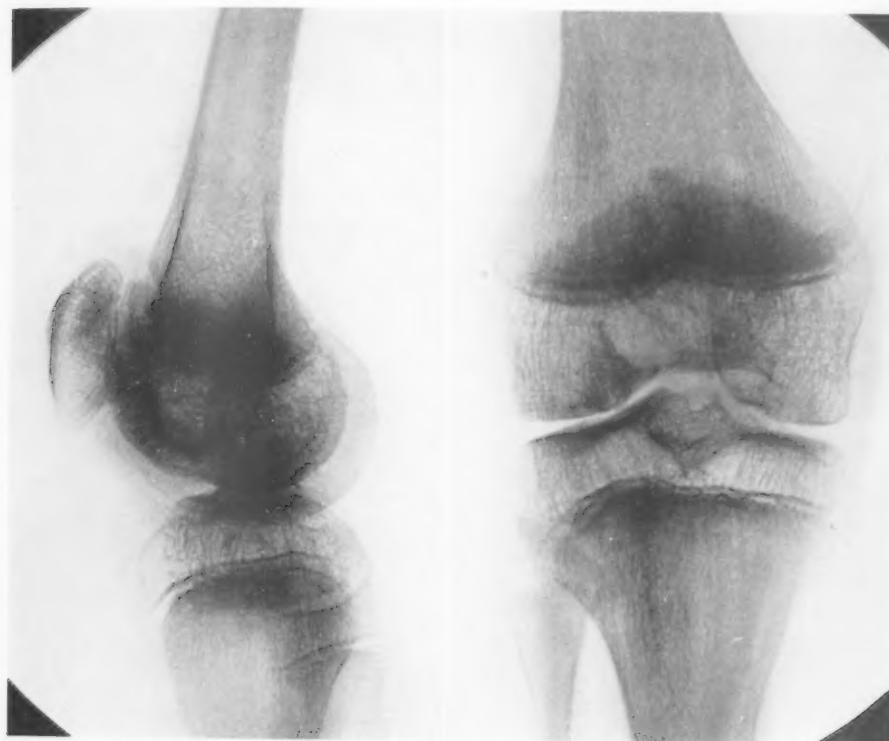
X-rays of knee of hemophilic arthritis before the operation. The characteristic dark shadows in the periarticular tissues do not show in the prints, but the larger rarefied areas may be seen in the femur and tibia.
